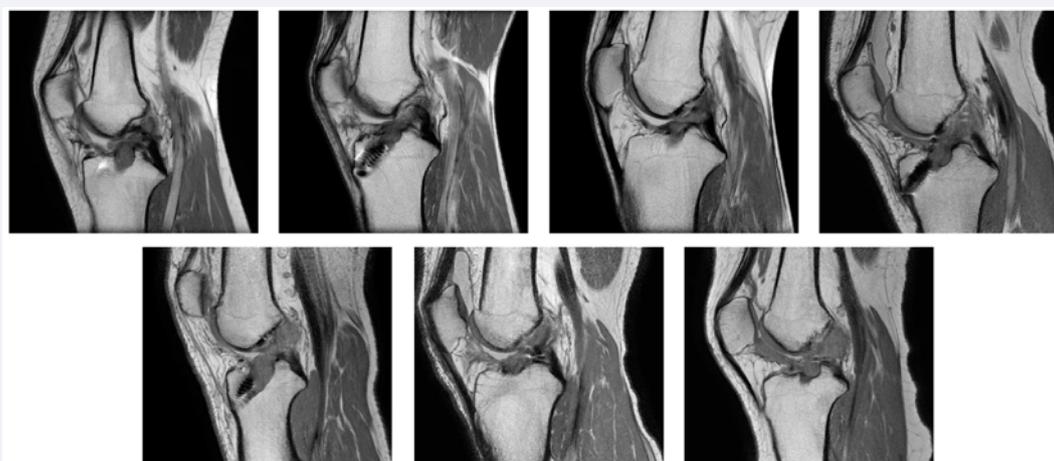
MRI taken at 12 months after ACL reconstruction. A hyper-intense signal was observed in the region of the graft, indicative of chronic inflammation and incomplete tissue maturation. A subset of patients also showed grafts with irregular contours and thinning (second image, upper row), as well as synovial effusion (lower row).
